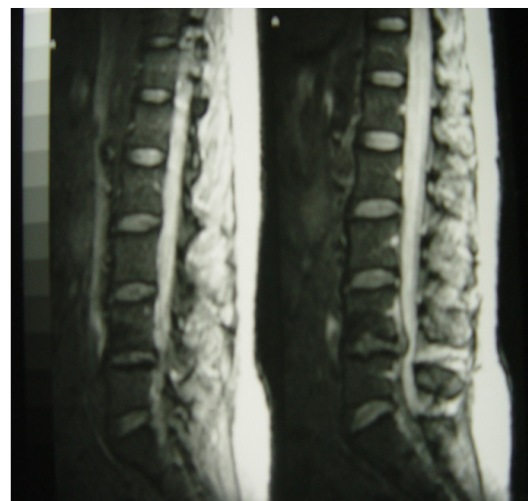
T2-weighted MRI shows extrusion at the level of L4-L5.
